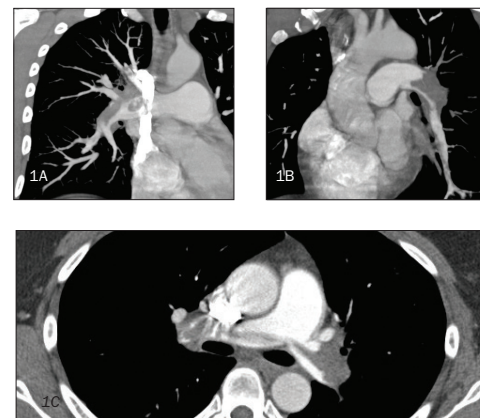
Pre-treatment CT angiography showed (A) thrombus in the right interlobar PA, (B) thrombus in the left PA, and (C) saddle embolus.
